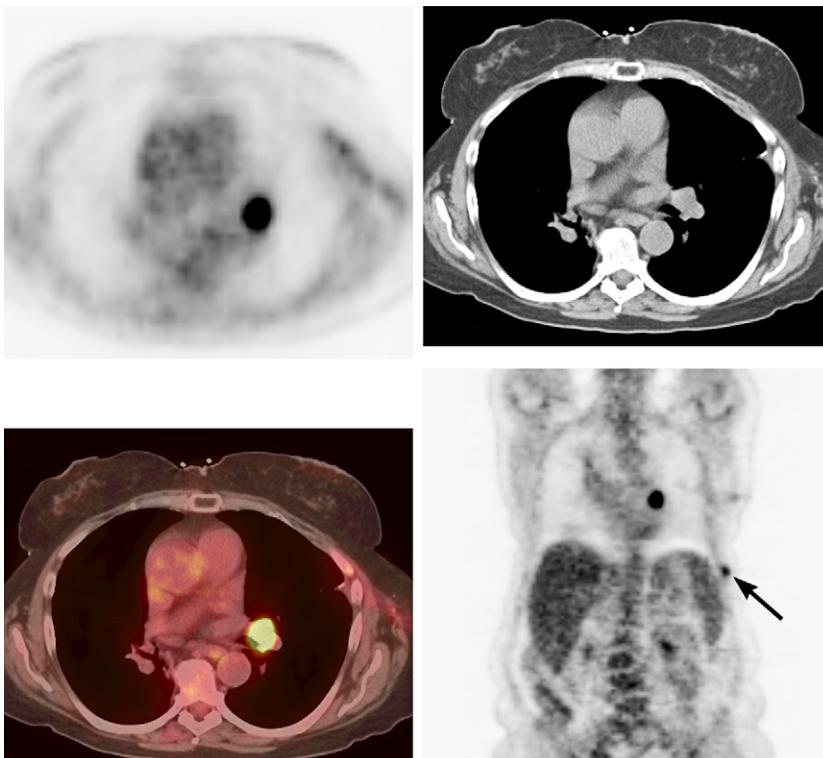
A 64-year-old woman following chemotherapy and radiation treatment for small cell carcinoma of the right lung developed a left hilar mass, which had increased uptake on an FDG-PET scan consistent with tumor recurrence. Focus of uptake in a left lower rib (arrow) is consistent with a new rib metastasis.
